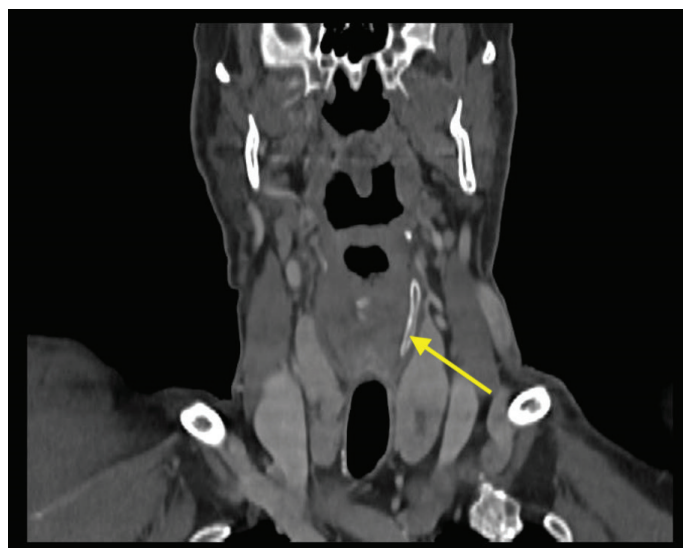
Computed tomography image in the coronal plane showing absence of the right superior thyroid cornu. The yellow arrow shows the left superior thyroid cornu for comparison
